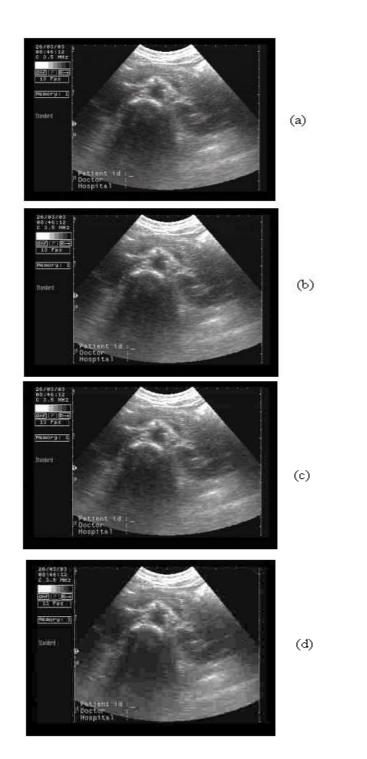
Ultrasound Images for abdomen, acquired by the OTELO system. (a) Original, uncompressed; (b) compressed with PSNR = 38 dB; (c) compressed with PSNR = 35.1 dB; (d) compressed with PSNR = 33.6 dB.
